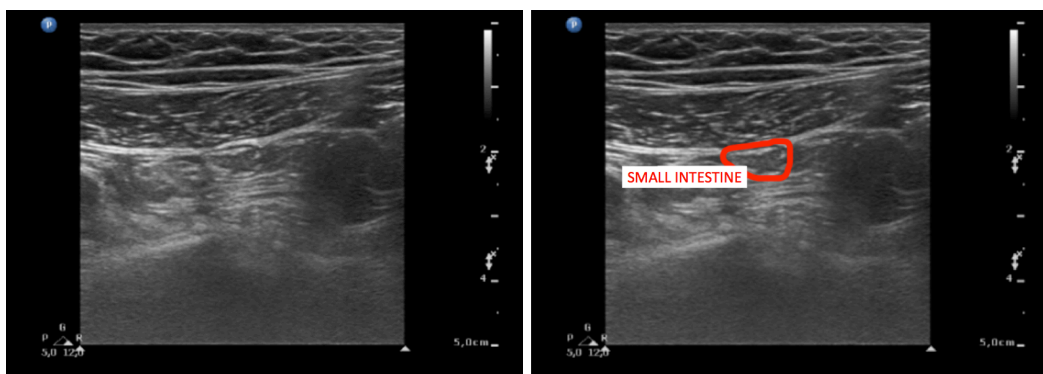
Ultrasonographic image of the small intestine.
